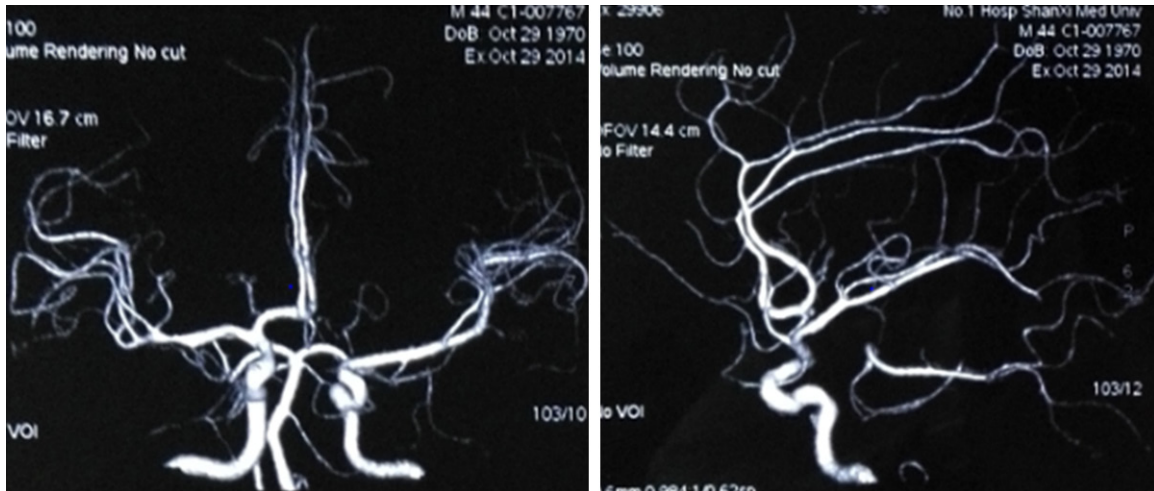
Cerebrovascular CTA.
